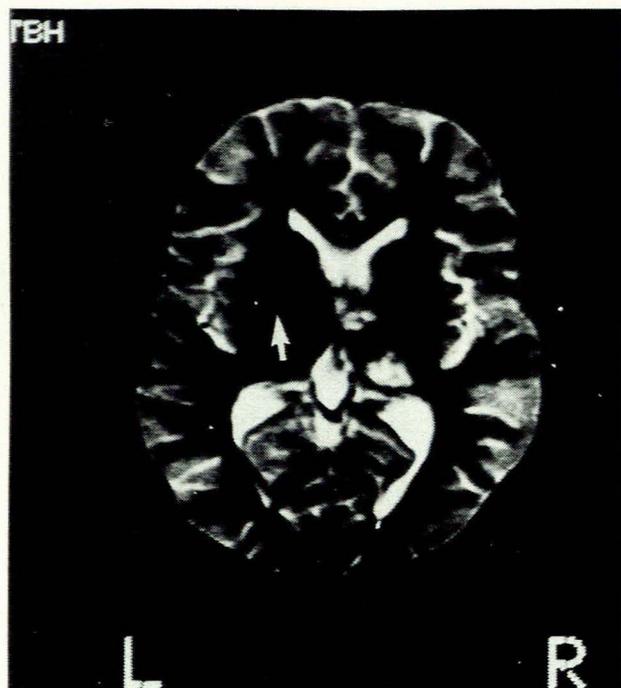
T2 weighted MRI revealing the same hyperintense lesions on the right with a further lesion involving the left putamen (arrow).
